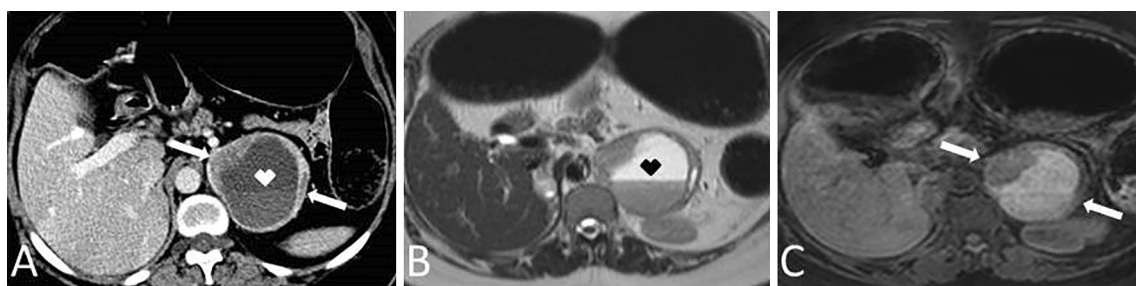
33-year-old female patient with known multiple endocrine neoplasia syndrome type 2B presenting with severe hypertension. A Axial postcontrast CT image shows a thick-walled cystic mass in the left adrenal gland (arrows). A fluid–fluid level (arrowhead) was also present due to intratumoral hemorrhage. B The fluid–fluid level
